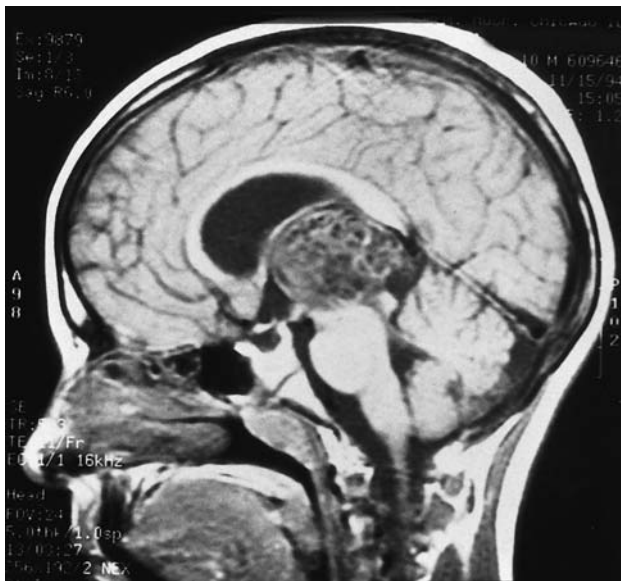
Midsagittal MRI showing a large teratoma in the pineal region extending into the third ventricle.
